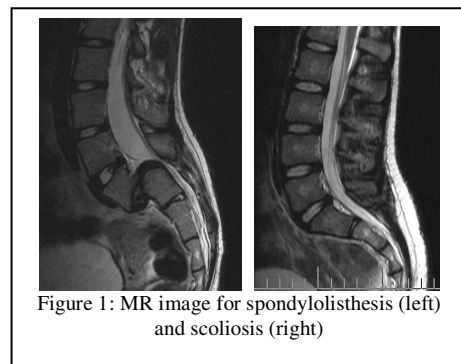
MR image for spondylolisthesis (left) and scoliosis (right)
